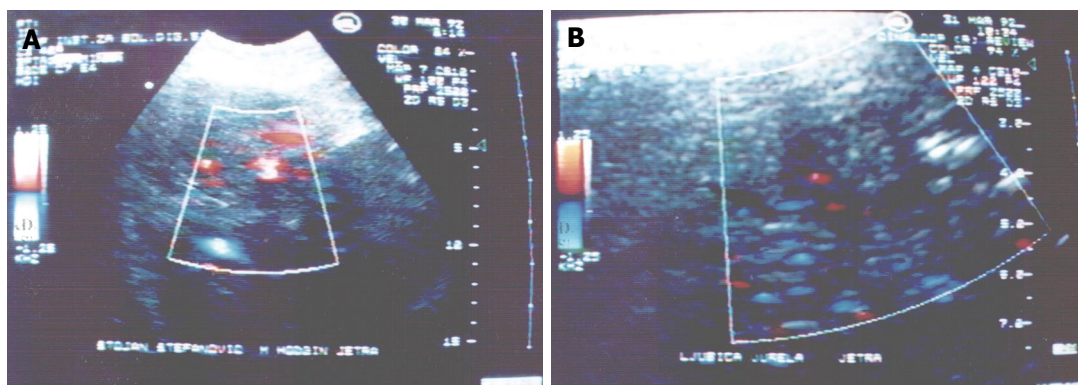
Color doppler ultrasonography. A: Intense-central neovascularization in the focal liver lesion; B: Intense peripheral neovascularization in the focal liver lesion.
